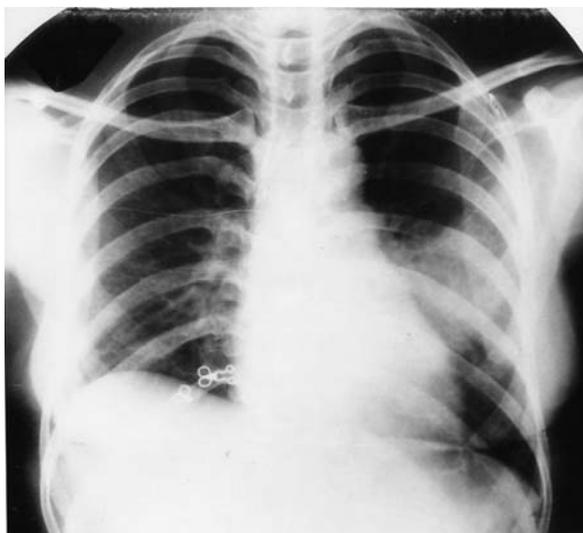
Plain chest roentgenogram showing consolidation predominantly in the left middle zone
